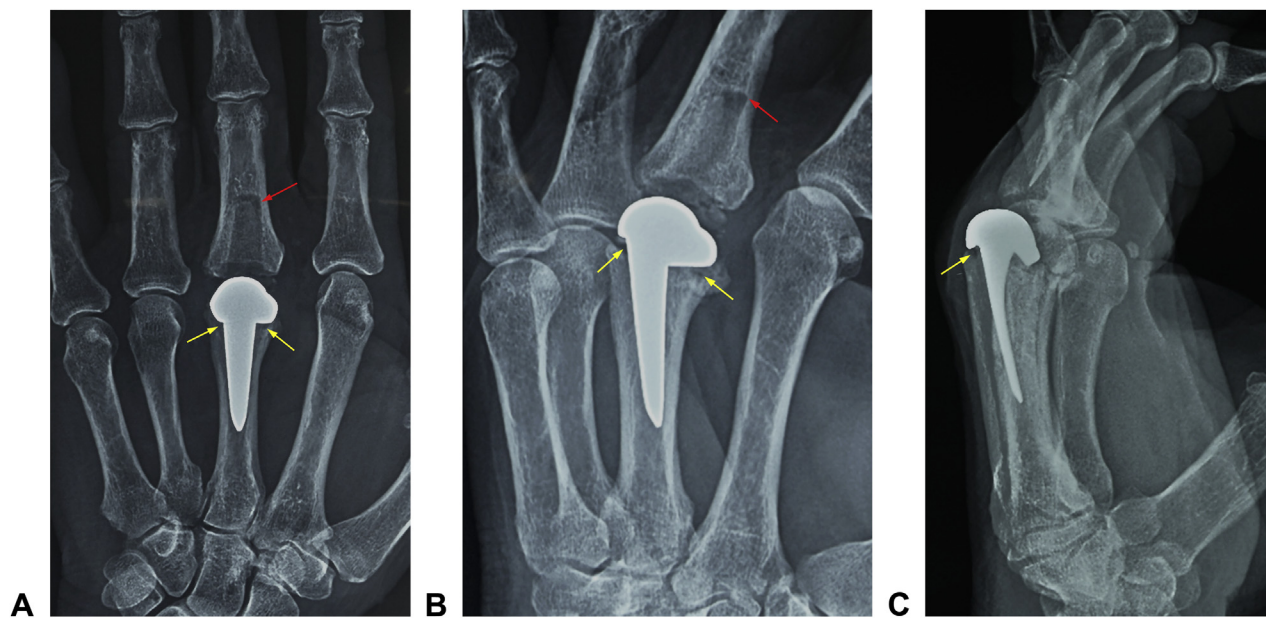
Plain radiographs demonstrate a third MCP prosthesis with discrete periprosthetic radiolucency. A Posteroanterior, B oblique, and C lateral views show osteolysis located between the head-neck junction of the metacarpal component and the bone (yellow arrows). A, B, Bone erosion is seen around the volar-radial cortex of the phalanx (red arrows).
